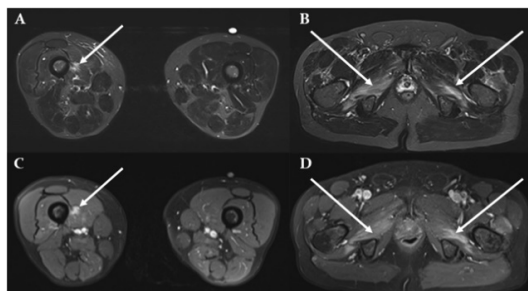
Pelvic and thigh MRI. (A) Thigh MRI in T2 STIR sequence showing oedema of the right vastus medialis (arrow). (B) Pelvic MRI in T2 STIR (short TI inversion recovery) sequence showing bilateral oedema of external obturator muscles (arrows). (C and D) T1 sequences revealing enhancement of muscle lesions after gadolinium infusion (arrows).
